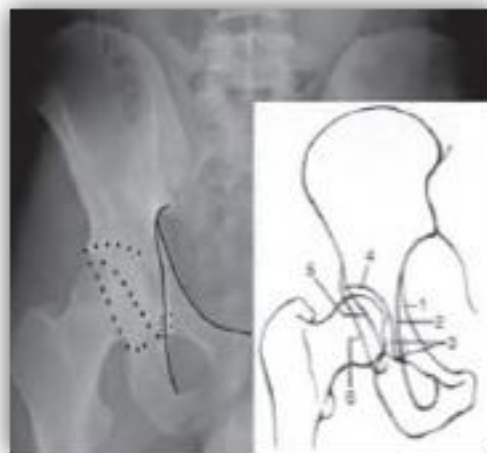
Radiographics lines of the acetabulum on Anteroposterior views. 1, iliopectineal line 2. Ilioischial line 3teardrop, 4. Acetabular roof, 5. Anterior rim of the acetabulum, 6. Posterior rim of the acetabulum.¹⁷
